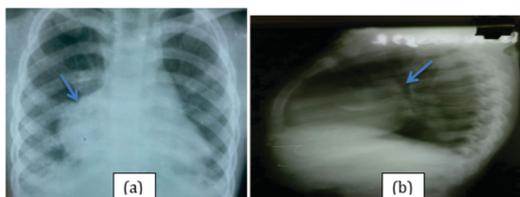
Image (a) showing abnormal convexity along right heart border. Image (b) showing retrosternal mass in x-ray lateral view. Image (c) coronal section CT chest and (d) axial section CT angiography showing mediastinal and intracardiac cystic lesion.
